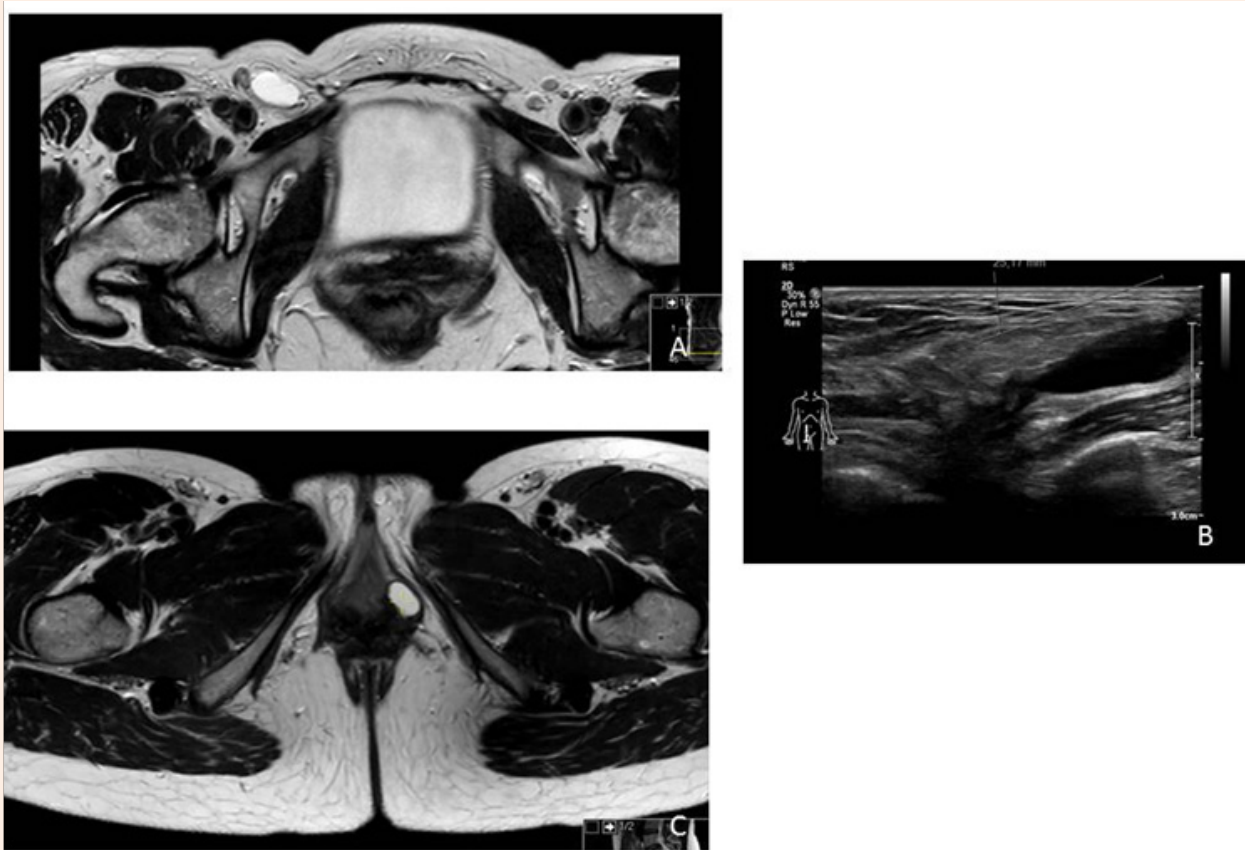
A. example of an MRI image of a cyst of Nuck.
